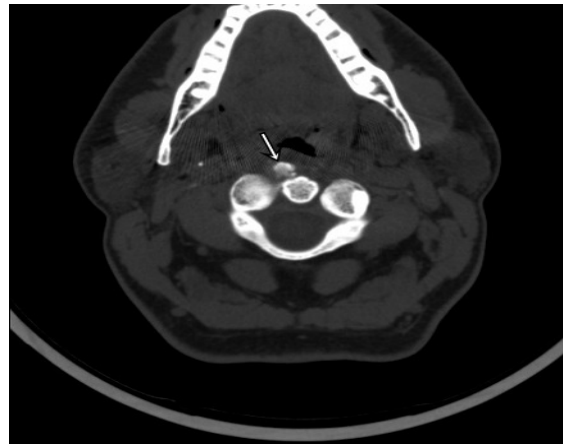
Axial CT image. Calcification and surrounding soft tissue swelling causes marked impression of nasopharyngeal space.
